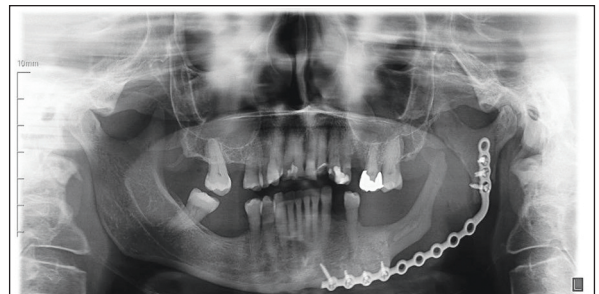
Bone regeneration in the operated area can be seen in the panoramic radiograph taken 3 years after the operation.
